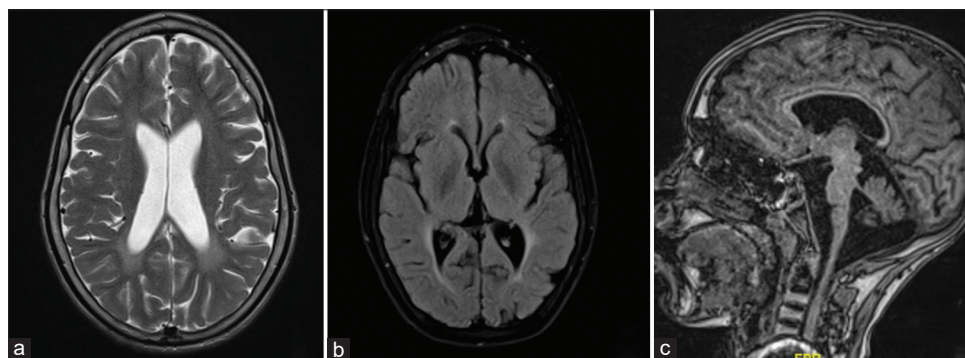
Magnetic resonance imaging of the brain with (a) T2 axial image showing hyperintensities in bilateral posterior periventricular parietal region with relative sparing of U fibers. (b) T2/FLAIR axial sequence showing periventricular white matter loss and ex vacuo dilatation of occipital horn of lateral ventricles. (c) T1 sagittal image showing diffuse thinning of corpus callosum with brain stem and cerebellar atrophy
